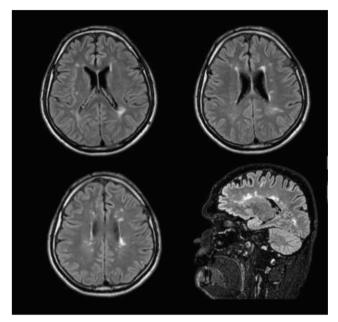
Periventricular and subcortical demyelinating lesions in the brain and in the corpus callosum shown by MRI scans (T2-weighted fluidattenuated inversion recovery) after ten infusions of durvalumab
